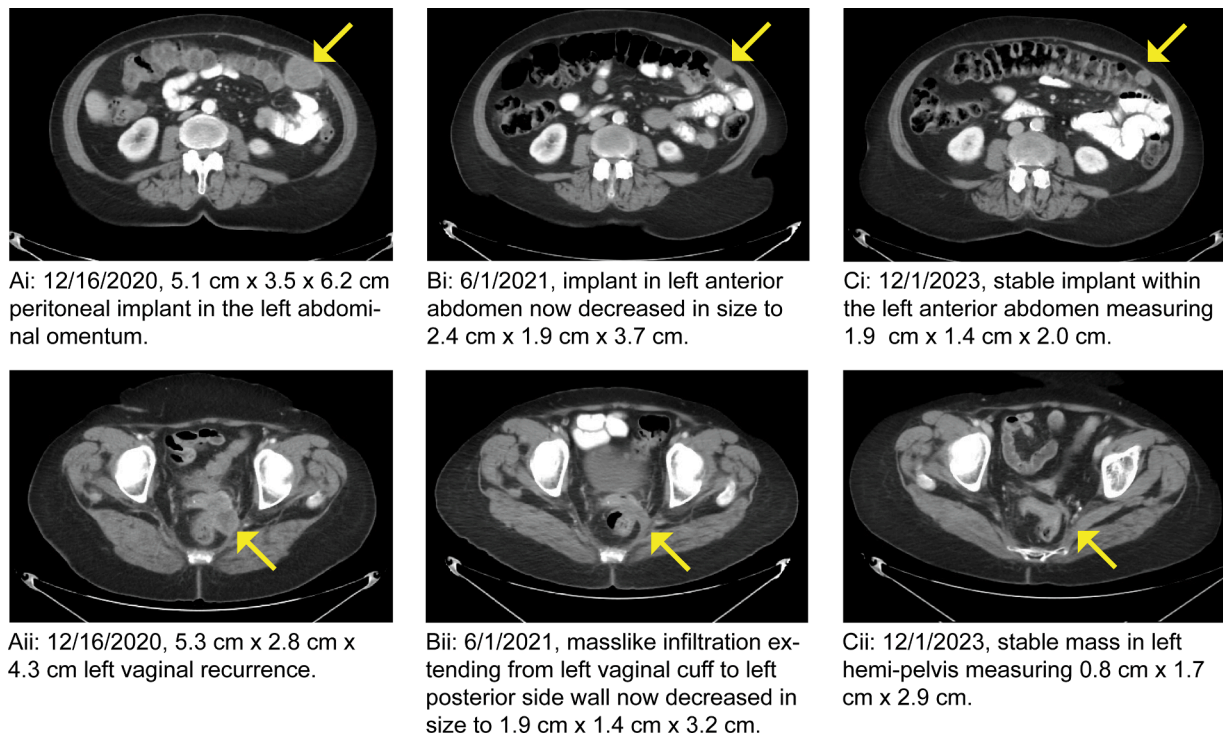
CT images of the abdomen (i) and pelvis (ii) demonstrating presence of left abdominal wall recurrence (Ai) and left vaginal recurrence (Aii), partial response after 6 cycles of pembrolizumab and lenvatinib (Bi, Bii), and sustained partial response after further treatment with pembrolizumab, lenvatinib and letrozole (Ci, Cii).
